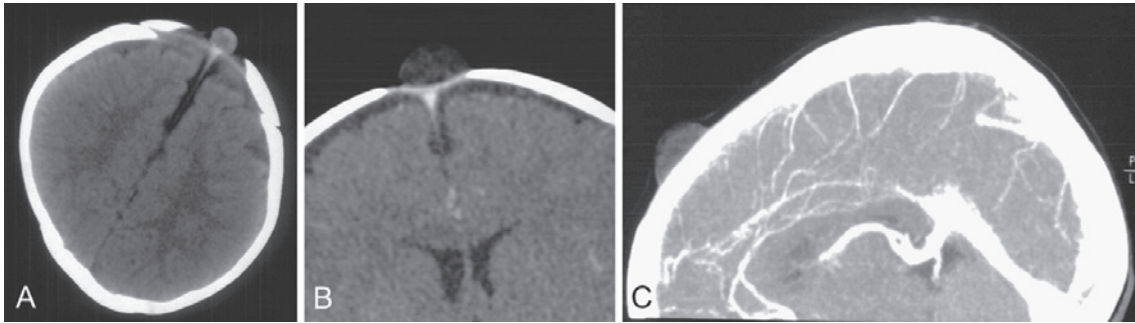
A) CT demonstrating a low-density to isodense round tumor at the center of the anterior fontanelle, which is open. B) On contrast-enhanced CT, the tumor does not show enhancement and is located at the center of the fontanelle. C) On reconstructed enhanced CT, no connection is apparent between the tumor and the superior sagittal sinus.
